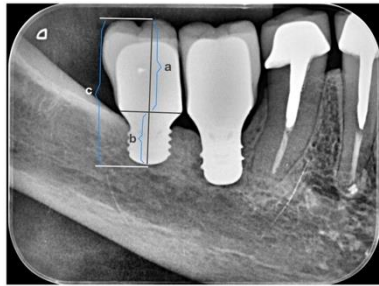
Radiographic crown-to-implant (CI) ratio measurements. (a) Anatomical crown length. (b) Anatomical implant length. (c) Anatomical CI ratio.
